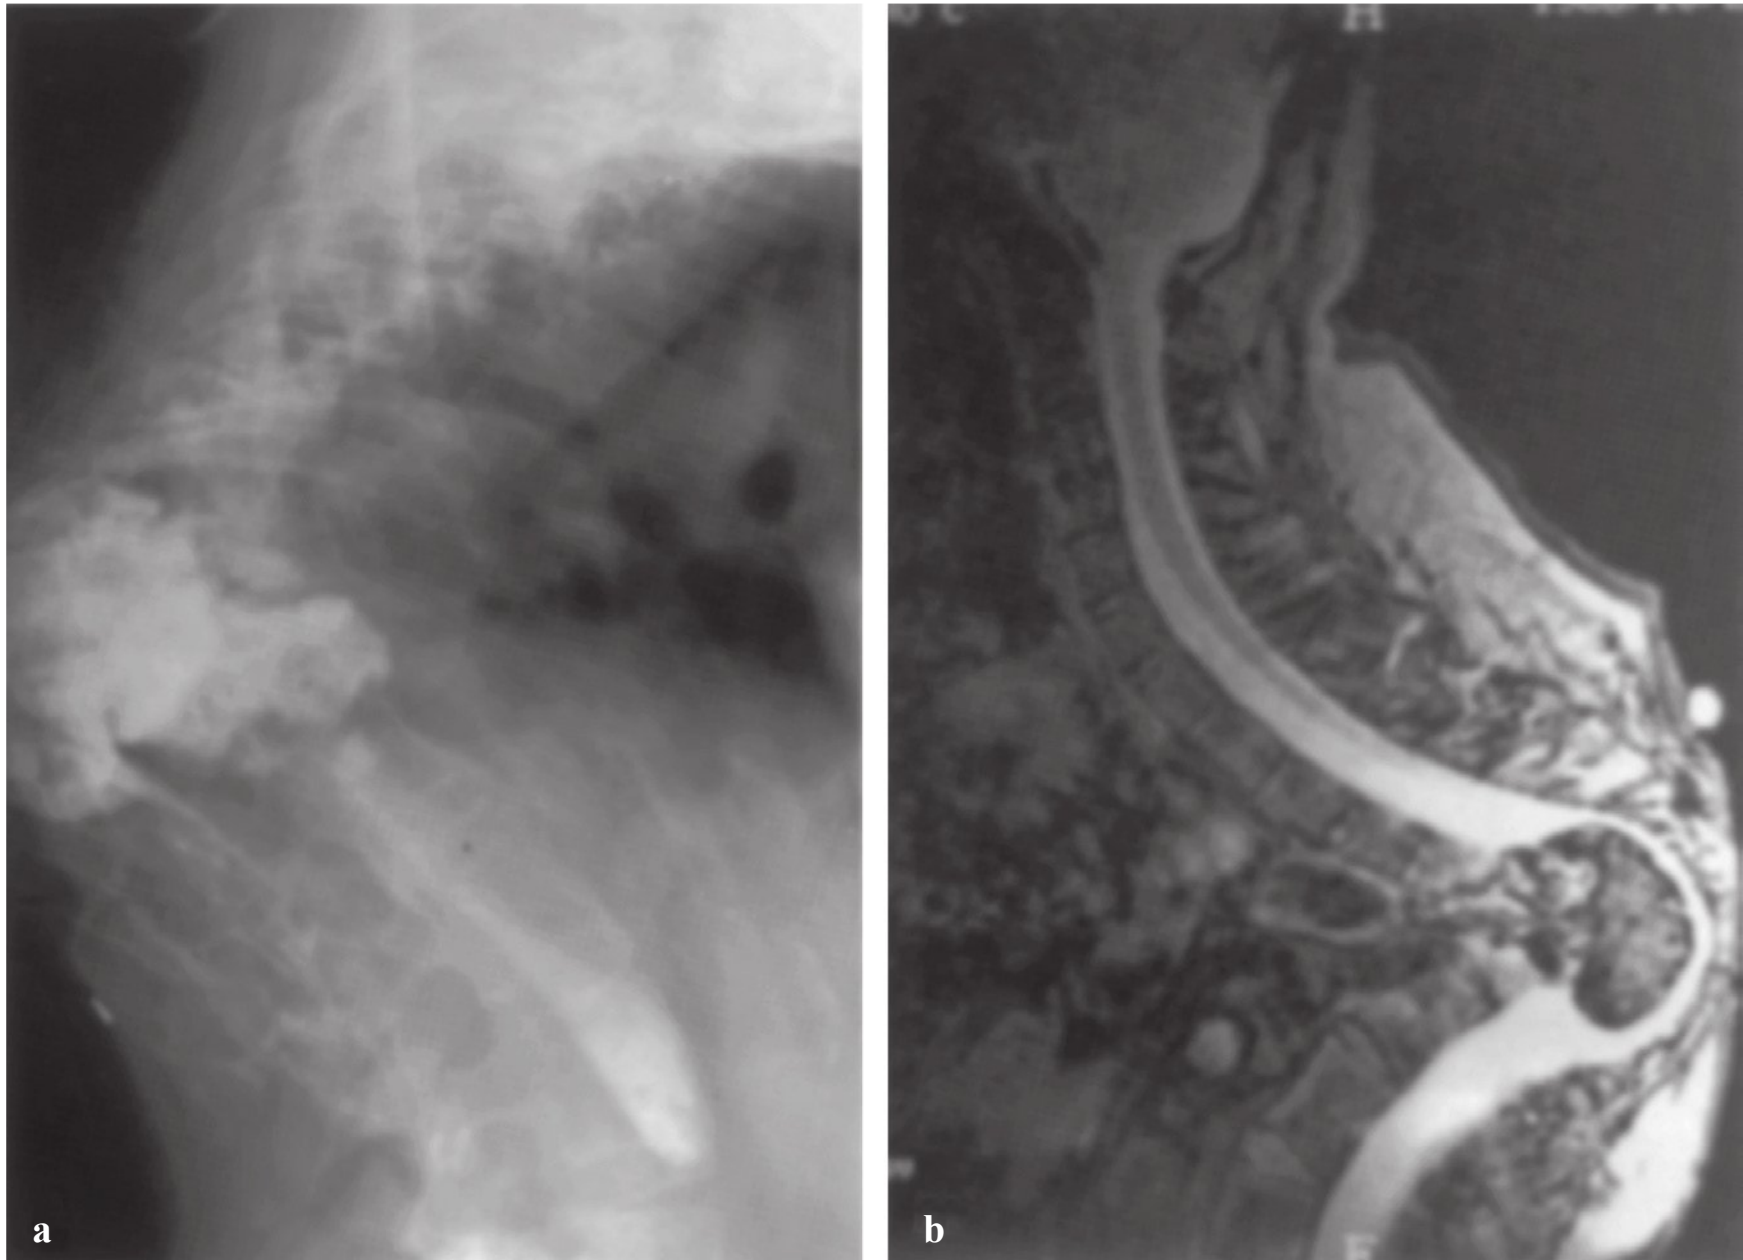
A 65-year-old man with old tuberculosis who had a posterior fusion 40 years prior. Despite severe kyphosis, this patient was ambulatory with minimal symptoms. (a) Lateral radiograph showing severe angular kyphosis. (b) Sagittal T2-weighted magnetic resonance image (MRI) showing an old granuloma and spinal cord compression at the apex of the kyphotic deformity.
